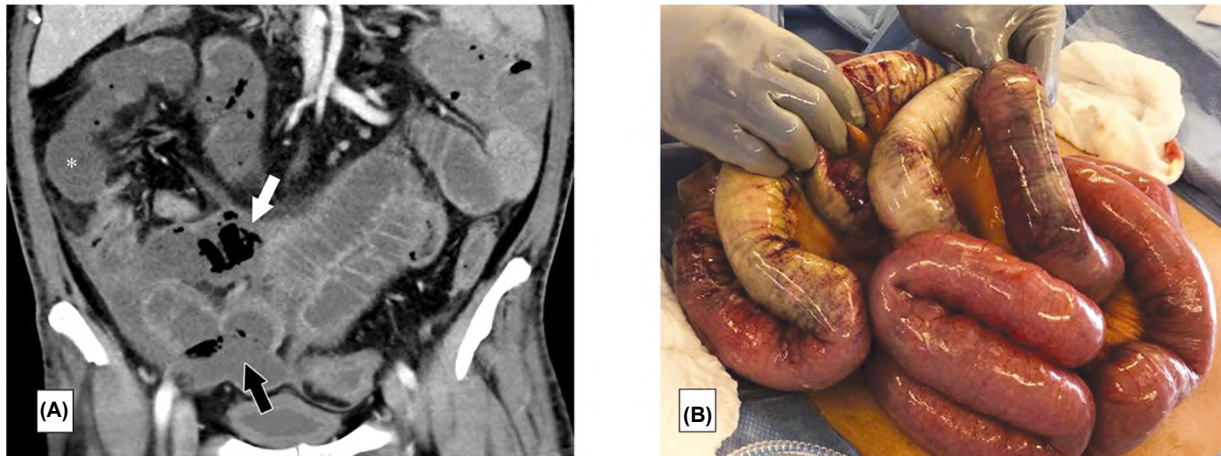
(A): Coronal contrast-enhanced abdominal CT image in a 47-year-old man with abdominal tenderness shows typical findings of mesenteric ischemia and infarction, including pneumatosis intestinalis (white arrow) and non-enhancing bowel. Frank discontinuity of a thickened loop of small bowel in the pelvis (black arrow) is in keeping with perforation. (B): These findings are confirmed at laparotomy, with the additional observation of an atypical yellow discoloration of the bowel (Bhayana et al., 2020).
